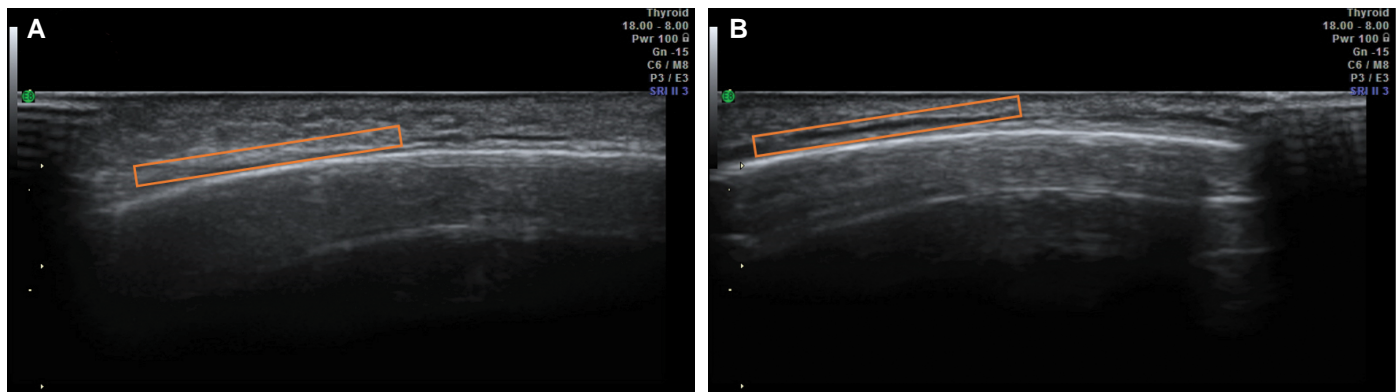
The figure displays an ultrasound scan of the *frontalis* muscle at baseline (A) and 3-month follow-up visit (B). An increase in contractile tissue in the region of interest, displayed as dark areas (framed area), is observed 3 months after the final treatment.
